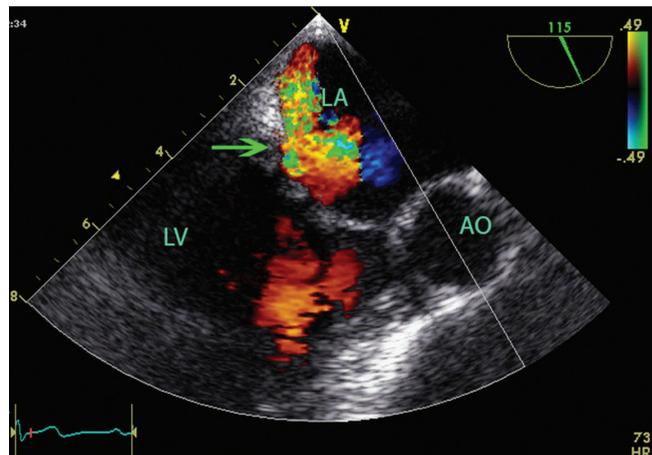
Transesophageal echocardiography in the long-axis view (115°) shows MR originating from the base of the PMVL (P3) (arrows).
